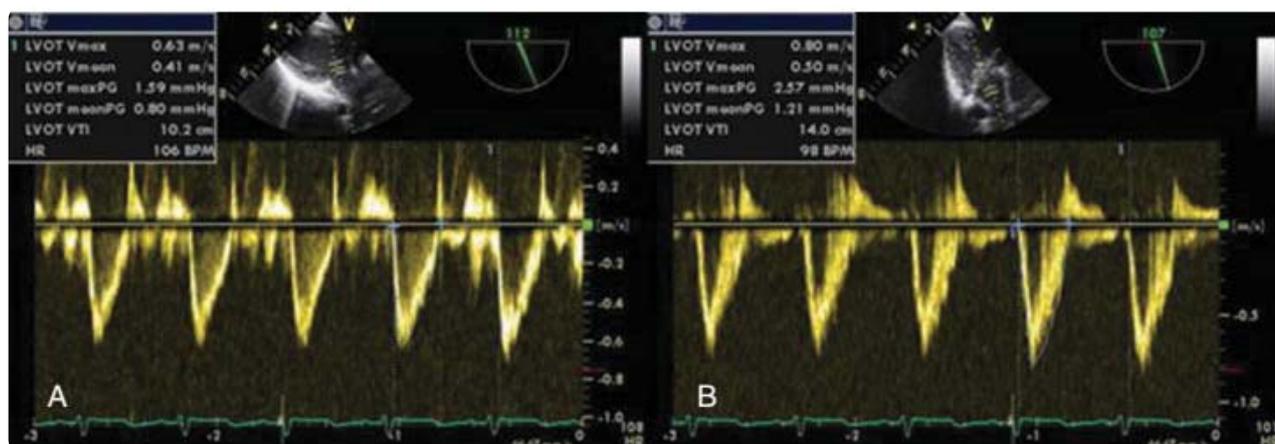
Measurement of Doppler velocity time integral in the LVOT (A) and in the ascending aorta (B) [44].
